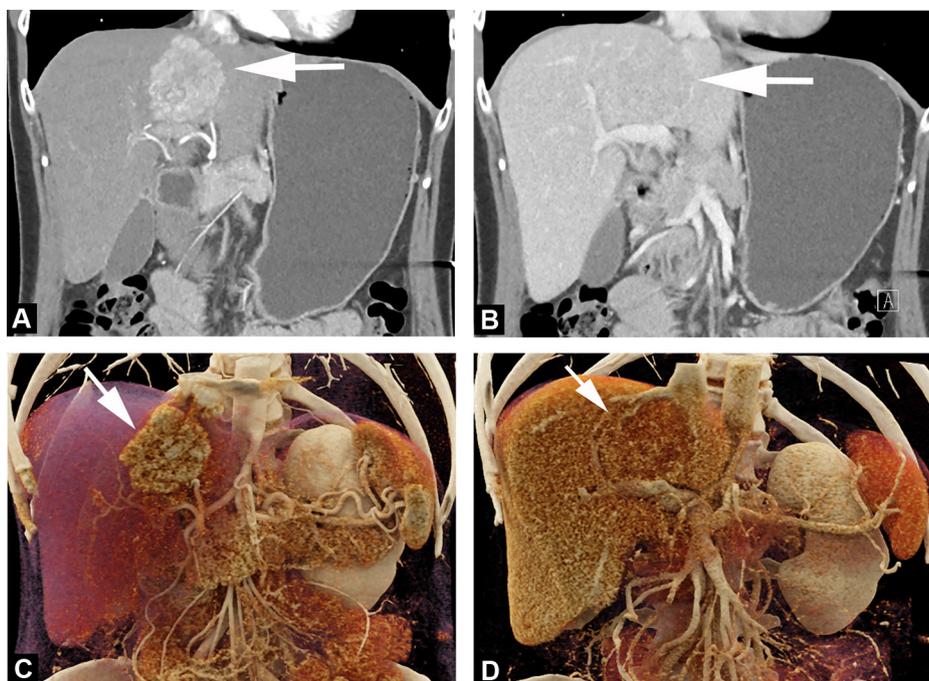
A 52-year-old woman with incidentally detected liver mass. A. Two-dimensional CT image obtained in the coronal plane during the arterial phase of enhancement shows an avidly homogeneously enhancing mass in the left medial section of the liver (segment 4) (arrow). B. CT image obtained in the coronal plane during the portal venous phase of enhancement with cinematic rendering shows that the mass becomes isoattenuating relative to background liver on venous phase (arrow), compatible with focal nodular hyperplasia. C and D. CT images obtained in the coronal plane during the arterial (C) and portal venous phase (D) of enhancement with cinematic rendering. Cinematic rendering images increase the conspicuity of the mass by varying the window level and width settings.
